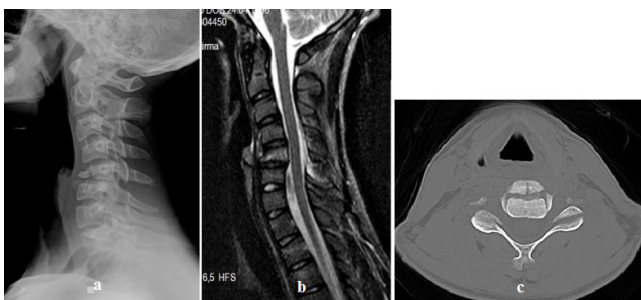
a) Preoperative sagittal X-Ray scan, b) Preoperative sagittal T2-weighted MRI scan and c) Preoperative sagittal CT scan.
